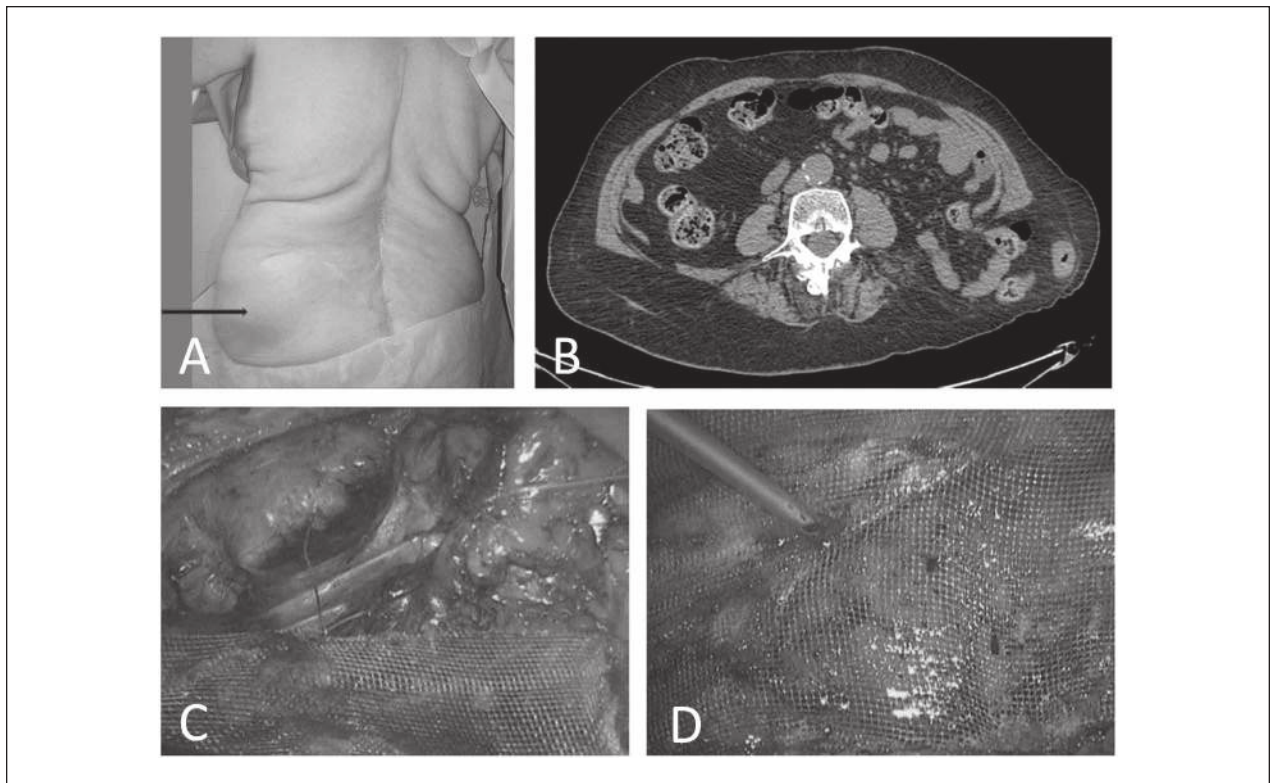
Lumbar hernia—laparoscopic surgery: (A) physical exam, (B) computed tomography study, (C) laparoscopy technique, and (D) mesh repair and fixation with synthetic tissular adhesive
